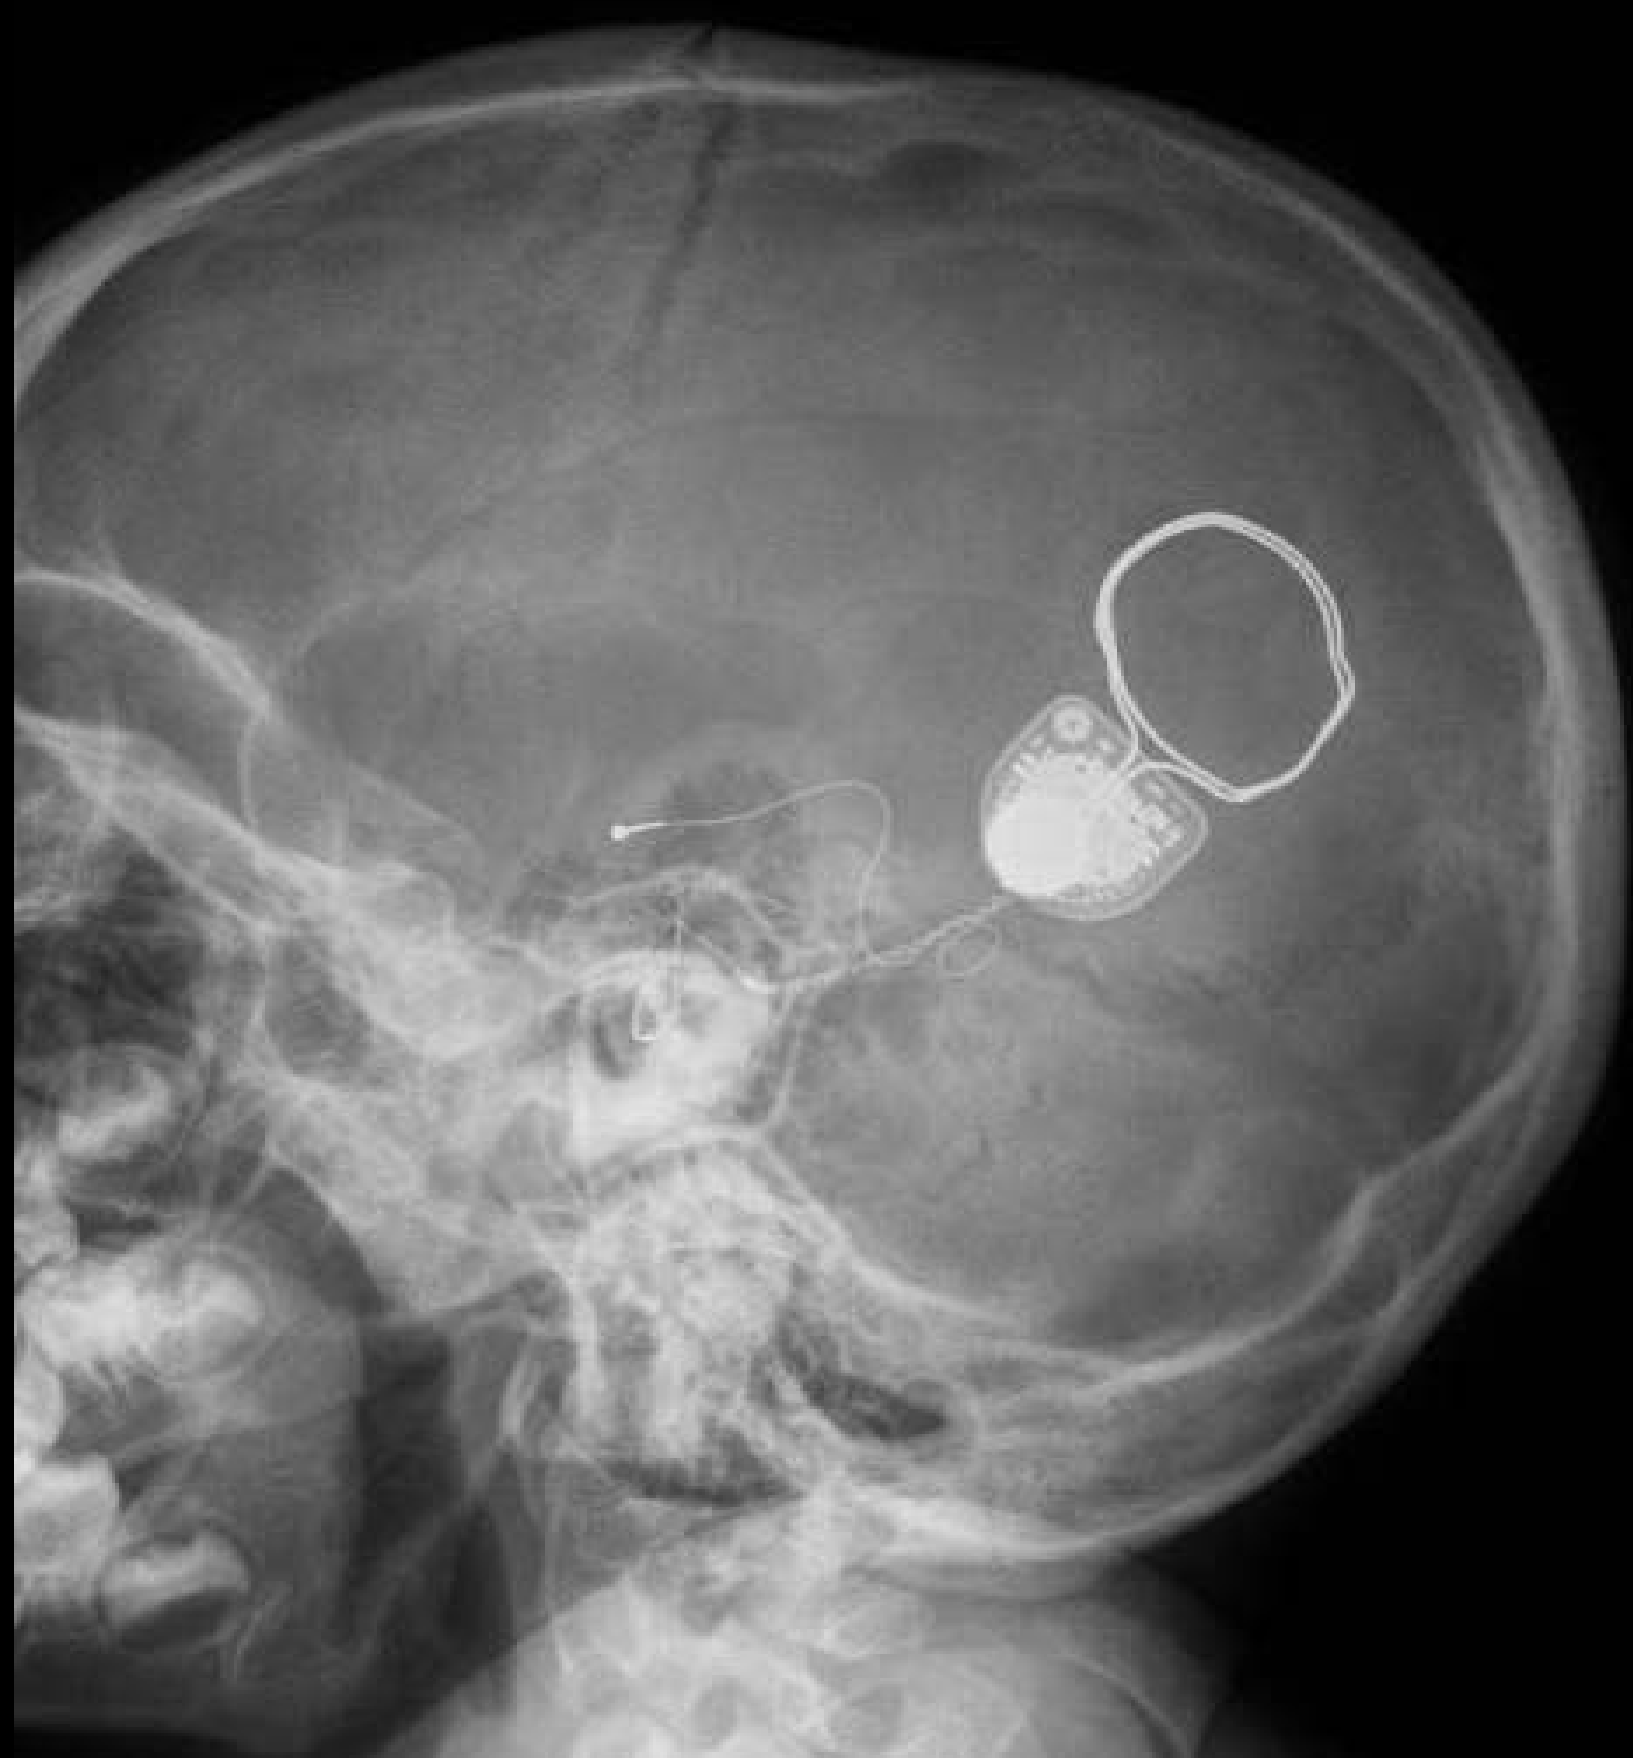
X-ray of cochlear implant with magnet displaced medial to implant
